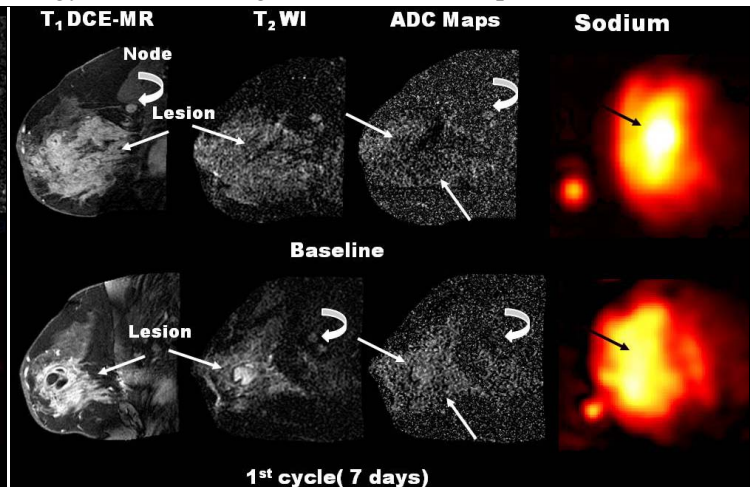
Representative 39 y/o patient with a T4dN0 lesion. Baseline DCE T1- and T2-weighted, DWI/ADC, and Sodium images demonstrating a large enhancing left breast lesion with heterogeneous ADC values and increased TSC. After PST, decreased enhancement in the lesion and increased ADC with small focal regions of decreased ADC. There was a decrease in the TSC. This patient was a responder.
